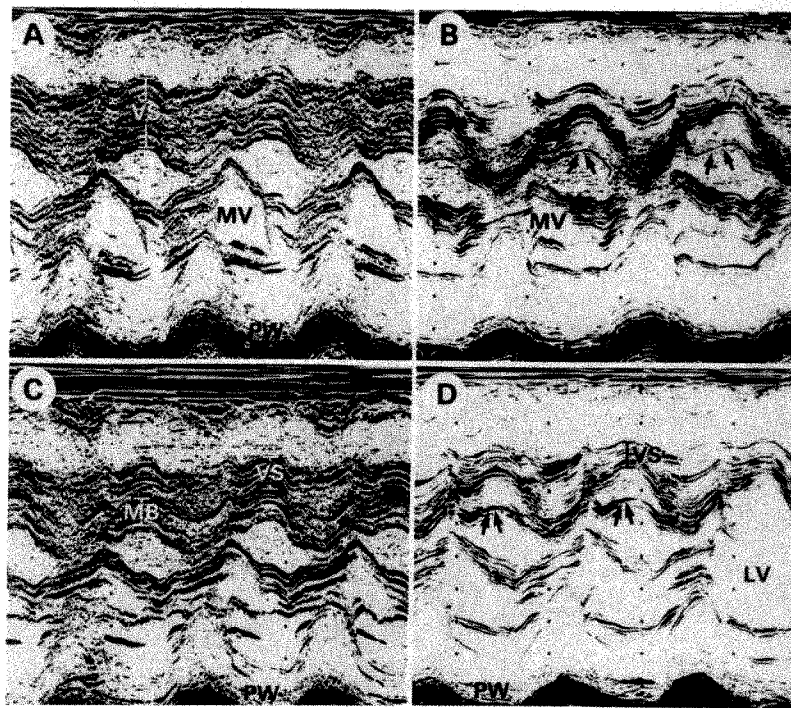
M-mode echocardiograms showing morphologic appearance of anterior or ventricular septum (VS) in the patient described. A and B, VS appears thickened (to 20 mm) due to contributions from true VS and the muscular band (MB), which appear to be contiguous in this plane; C and D, after mild angulation of the transducer the muscular band (arrows) has been separated from the true VS, which now appears to be of normal thickness (10 mm). Calibration marks are 1 cm apart. LV = left ventricle; MV = mitral valve; PW = posterior left ventricular free wall.
